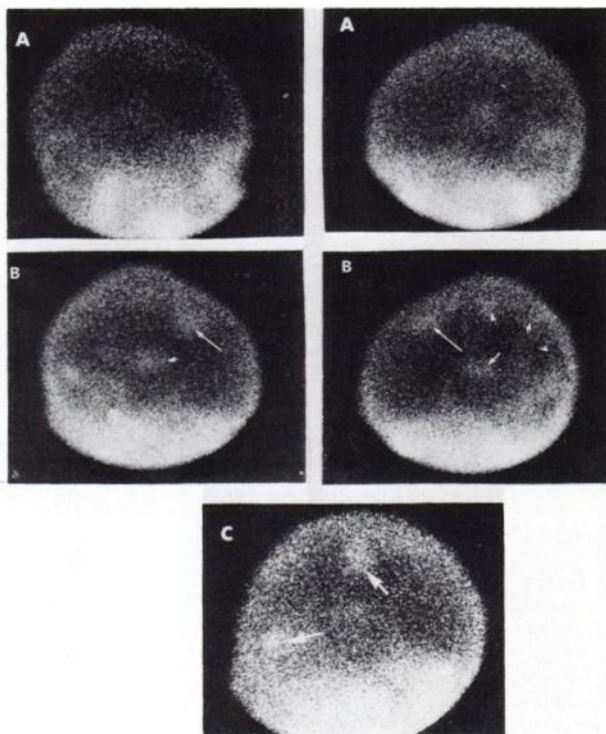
Multiple metastases from carcinoma of the breast, right and left lateral projections. (A) Five-hour per technetate images indicate only the left parietal growth. (B) Four-hour glucoheptonate scintigrams clearly show five or six lesions. (C) Only the 9-hr glucoheptonate image (right, lateral) revealed "oat-cell" lesions in right parietal and occipital regions.
